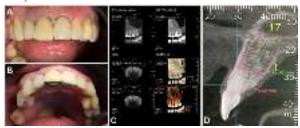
A) Pre-treatment frontal aspect; B) Occlusal view pretreatment; C-D) CBCT images of jaws.
